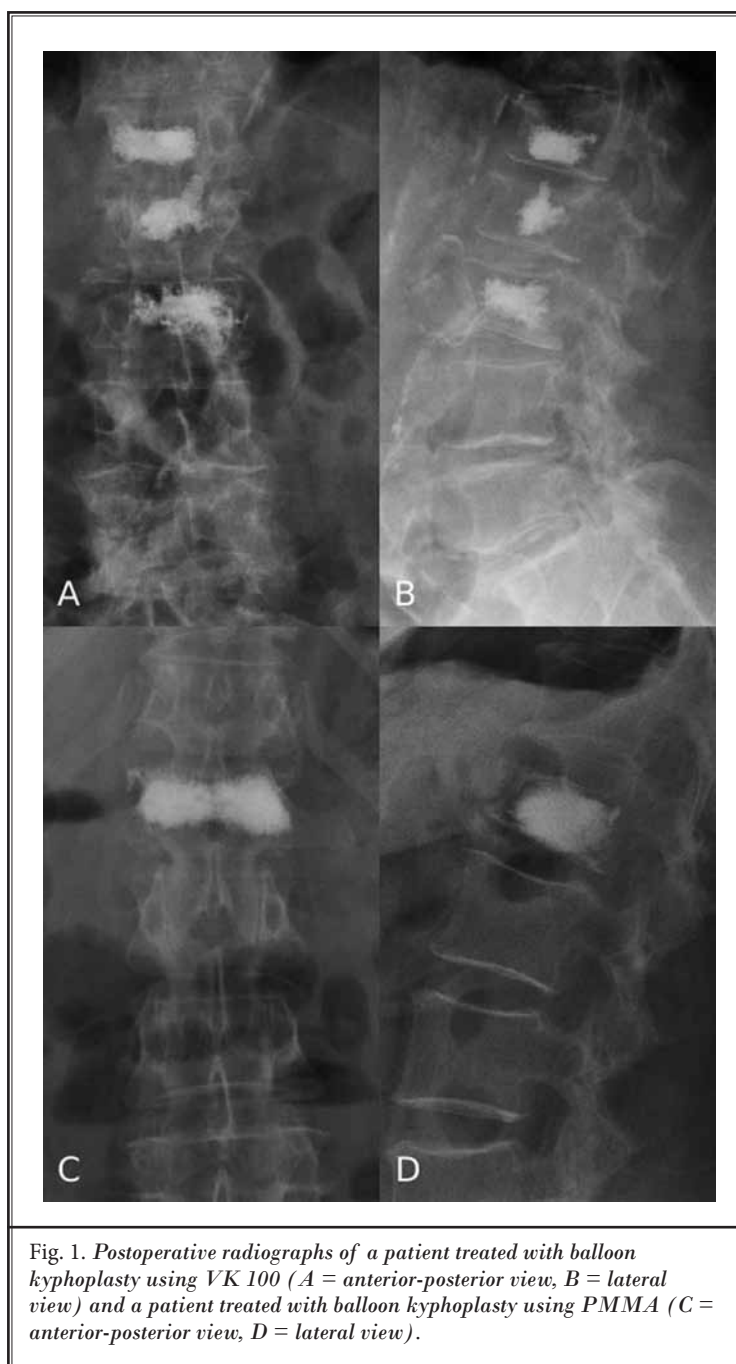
Postoperative radiographs of a patient treated with balloon kyphoplasty using VK 100 (A = anterior-posterior view, B = lateral view) and a patient treated with balloon kyphoplasty using PMMA (C = anterior-posterior view, D = lateral view).
